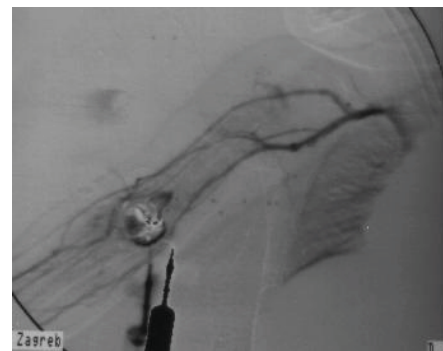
CT angiography with contrast.
